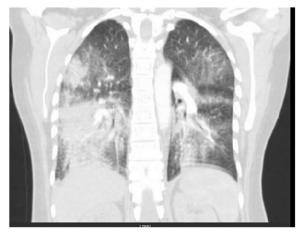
CT Chest axial view showing bilateral lung infiltrate progression over 1 month.
